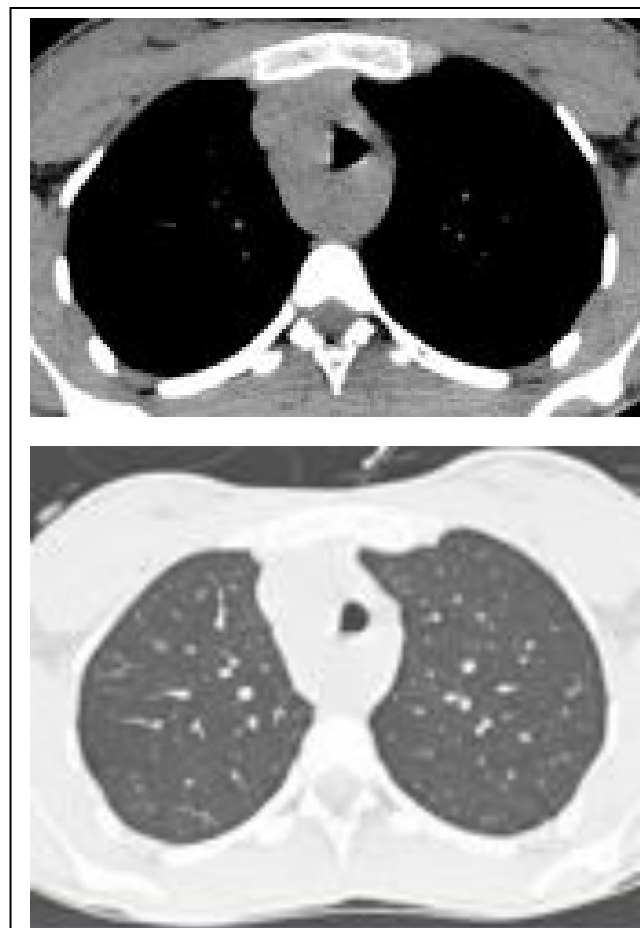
Thoracic CT images showing the right sided arcus aorta and tracheal compression(patient in 1st Figure).
